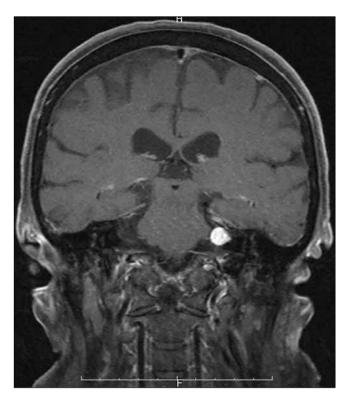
Coronal T1-weighted post contrast MRI demonstrate a post contrast enhancing small acoustic neuroma in the left cerebellopontine angle.
